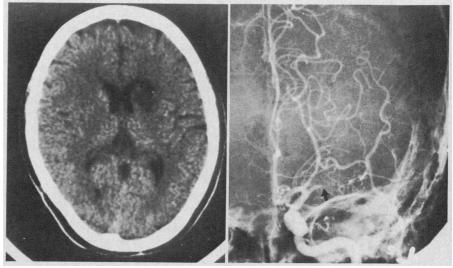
Left, Computed tomographic scan without contrast showing infarct in the anterior limb of the internal capsule and white matter adjacent to the caudate nucleus. Right, Carotid angiogram, anteroposterior view. Occlusion of proximal middle cerebral artery (black area) before medial lenticulostriate branches. The posterior cerebral artery fills from the internal carotid artery directly.
